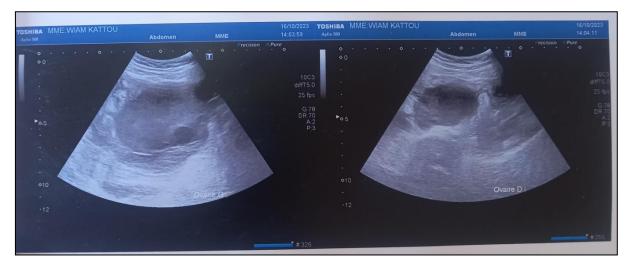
Ultrasound showing the two ovarian masses
